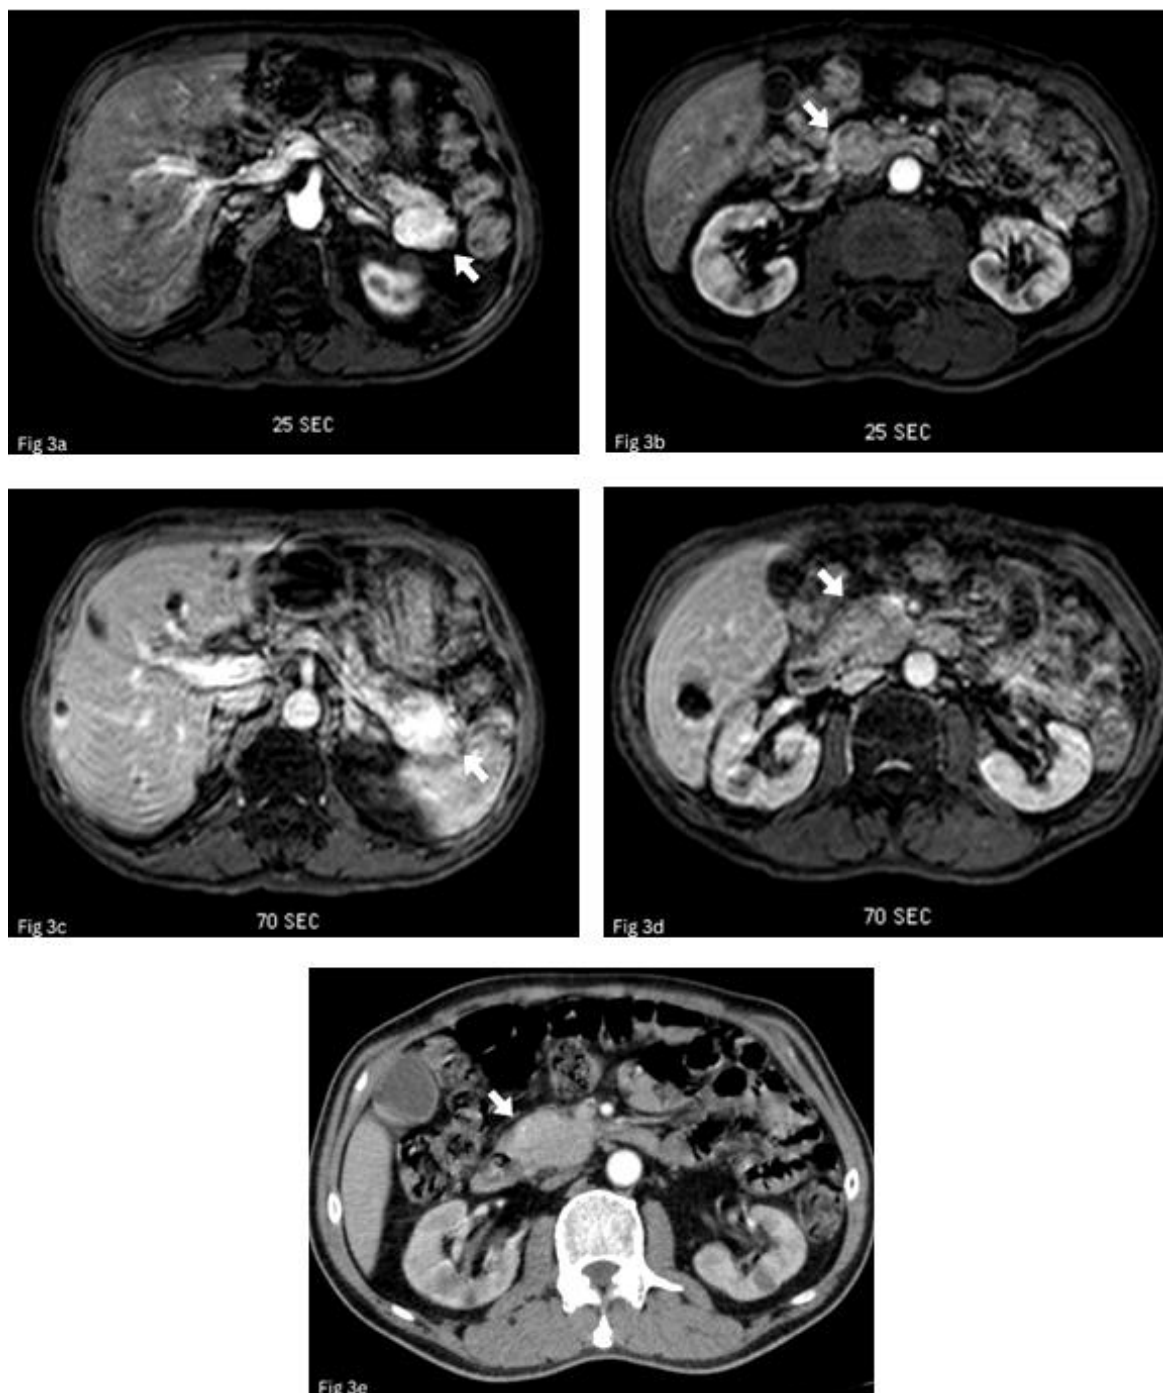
(a) MRI A-phase showing enhanced nodule at tail of pancreas, the hyposignaling lesions in liver are liver cysts (b) MRI A-phase showing another 2.8 cm hypointense lesion at uncinate process of pancreas (c) MRI V-phase lesion at tail of pancreas (d) MRI V-phase lesion at uncinate (e) reviewing first CT scan shows mildly enhancing mass like lesion at uncinate
